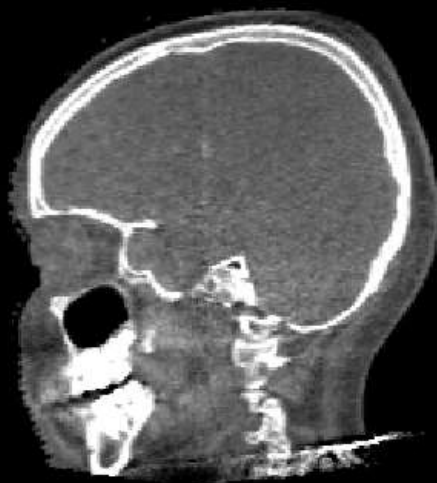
Image Guide RT: Cone Beam CT
